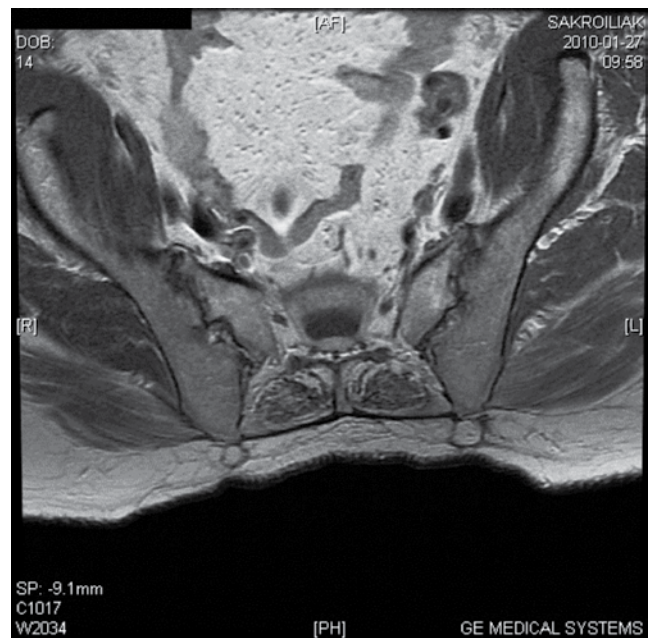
Sacroiliac magnetic resonance imaging shows joint distances narrowing, irregularity, erosion, sclerotic changes and the apparent bilateral chronic sacroileitis
